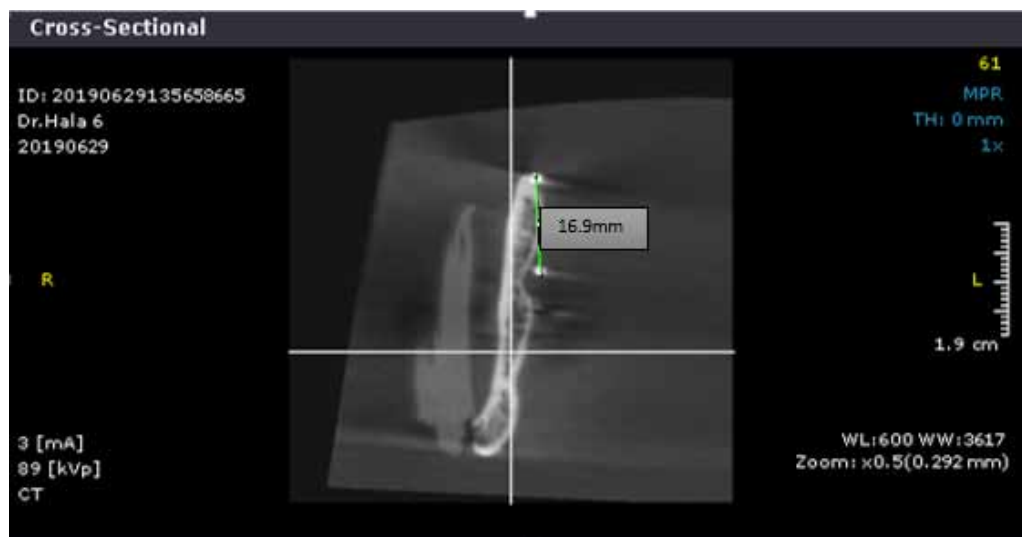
ab linear measurement performed on cross sectional image of cone beam computed tomography.
